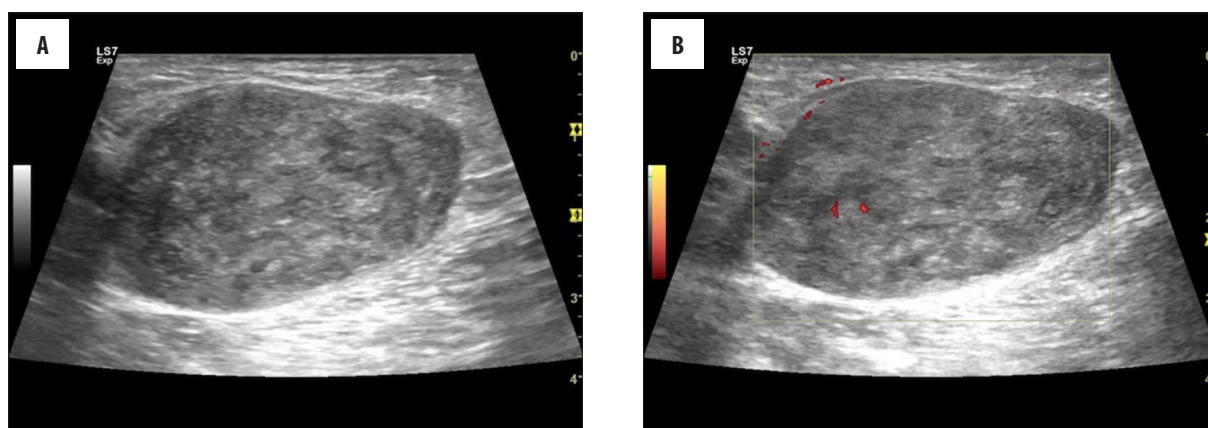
A well-demarcated ovoid-shaped mass with mixed echogenicity in the left inguinal area on ultrasound (A). Power Doppler imaging revealed minimal vascularity within the mass (B).
